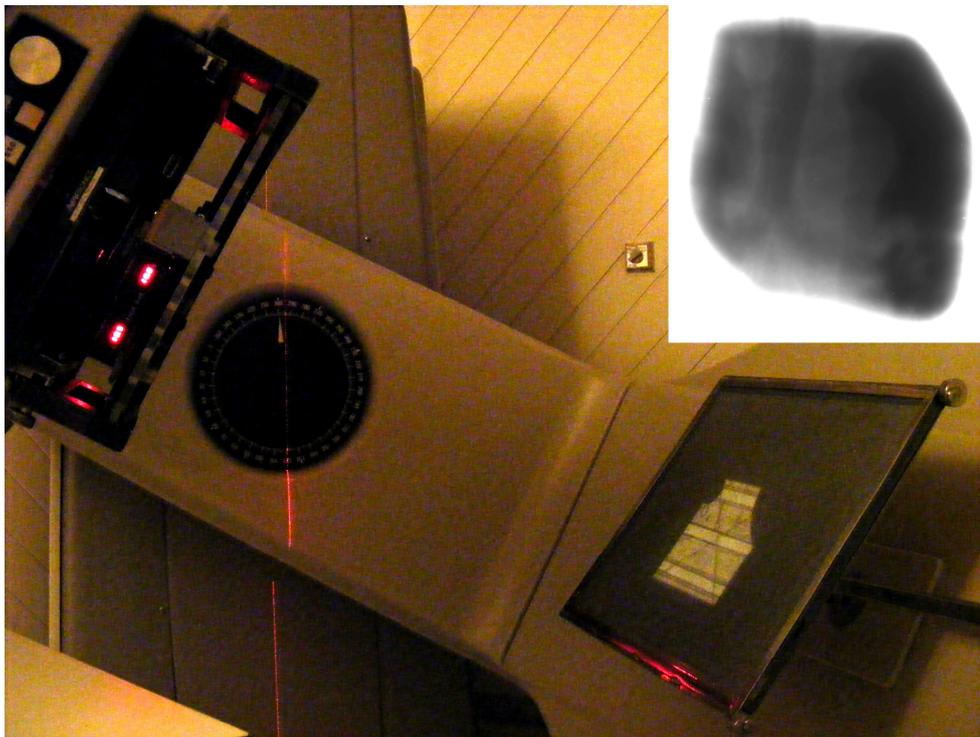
position verification with X-ray film³
